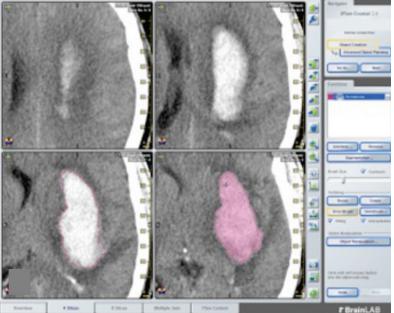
(A) Axial computed tomography scan slice displaying the method of linear measurement using DicomWorks software; (B) definition of the hematoma borders using Iplan (BrainLab, München).
